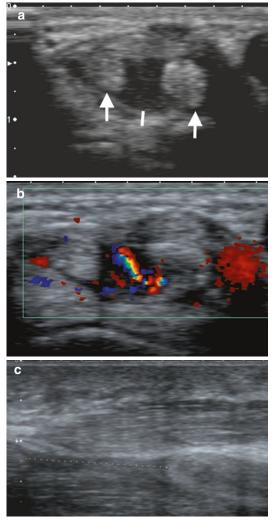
A 42-year-old female with long-standing SLE presenting with acute tenosynovitis, (a) transverse ultrasound dorsal wrist, fourth extensor compartment, with enlarged tendons with heterogeneous echotexture (*arrows*) and tendon sheath distension (*line*); (b) marked increased flow within the tendon sheath in keeping with active synovitis; and (c) different patient with rupture flexor pollicis longus tendon, separated tendon ends indicated by a *dashed line*
